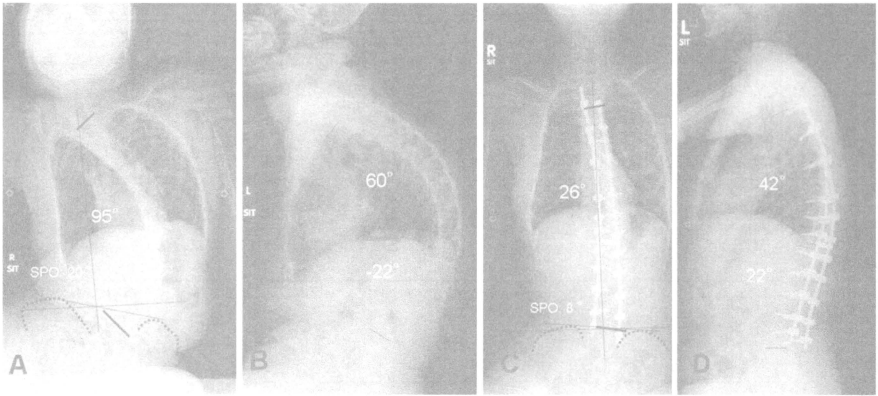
A, B A 13-year-old boy with Fukuyama congenital muscular dystrophy. Sitting preoperative anteroposterior radiograph shows a severe (95°) thoracolumbar curve. C, D Surgical correction of scoliosis was performed successfully.
